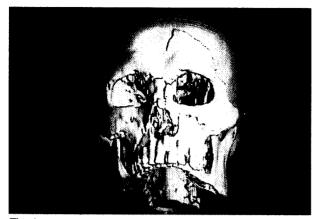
Preoperative 3D CT finding
